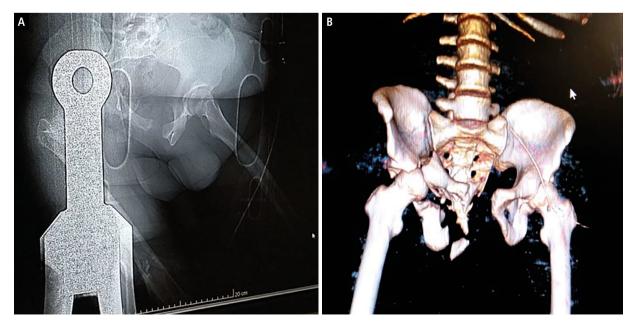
A. X-ray of victim pelvis with foreign body; B. 3D computed tomography reconstruction of patient's femur and pelvis
